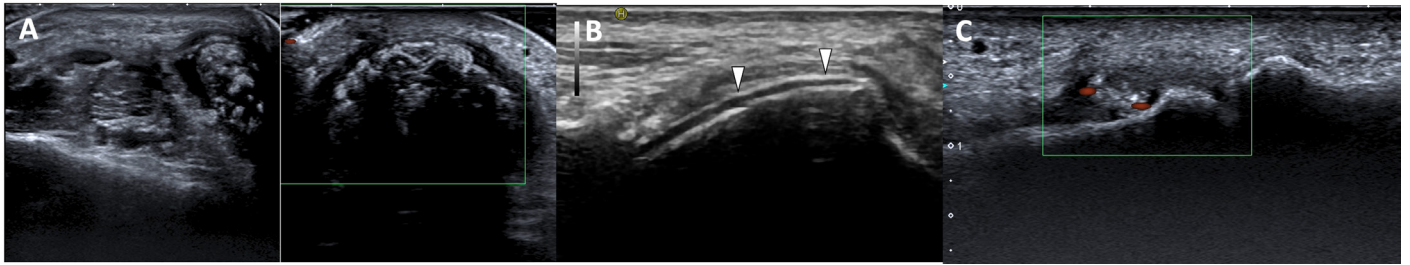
Combined grayscale and Power Doppler ultrasound showing subcutaneous tophus with heterogeneous echotexture and minimal internal vascularity (A). Grayscale ultrasound demonstrating “double contour sign” (white arrowheads) representing crystal deposition on cartilage surface (B). Power Doppler ultrasound of tophaceous lesion (green box) showing increased perilesional vascularity indicating active inflammation (C).
